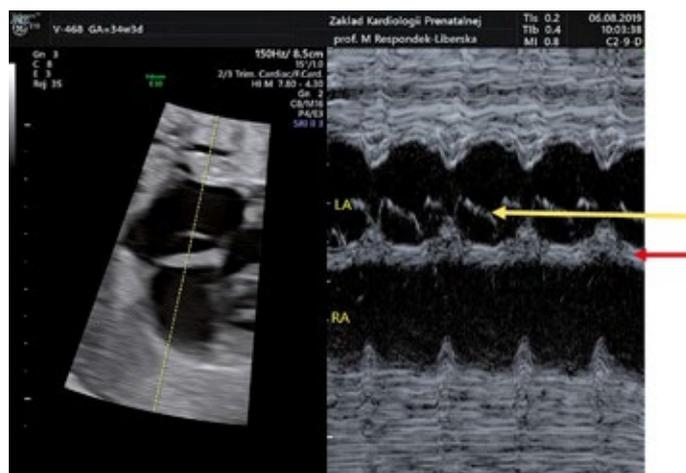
M-mode RA/LA echocardiography images. Yellow arrow – foramen ovale flap within the space of left atrium (LA), red arrow – atrial septum
